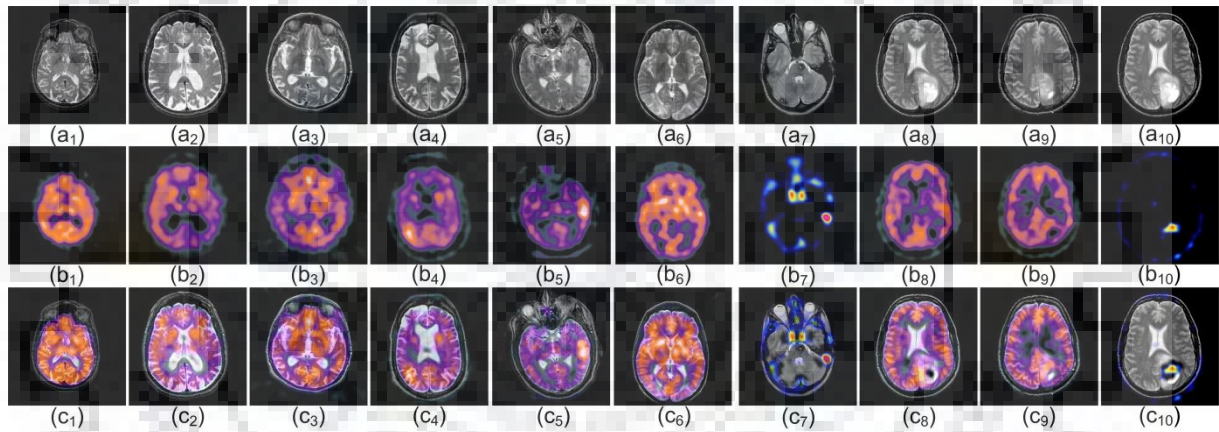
(a) Source MR images, (b) SPECT images (c) Fused images obtained by the proposed ADP-MIF approach
